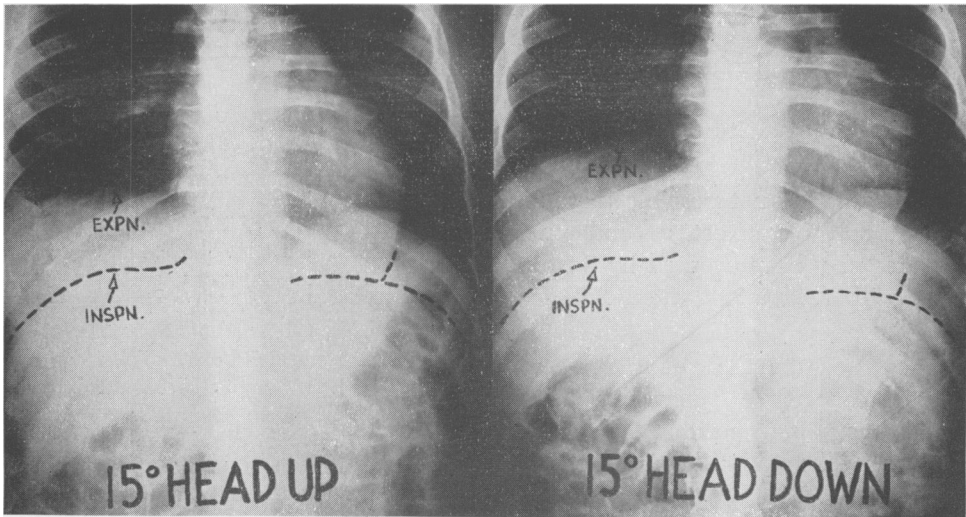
Roentgenograms of a quadriplegic patient taken during full expiration in the 15° head-up and 15° head-down positions. The location of the diaphragm in roentgenograms taken in each position during full inspiration has been traced as a dotted line.
